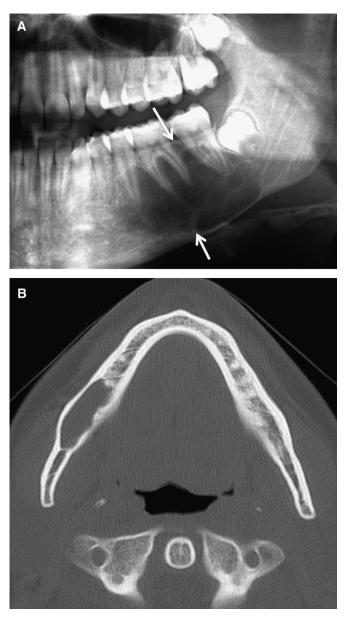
(A) A magnified panoramic radiograph of an simple bone cyst. Note the scalloped borders around the roots of the teeth and the endosteal surface of the outer cortical boundaries (white arrows). (From Oral Radiology. 5th ed. White and Pharoah, Mosby, 2004, with permission.) (B) An axial computed tomography image of a simple bone cyst occupying the body of the mandible, with minimal expansion and mildly scalloped margins.
